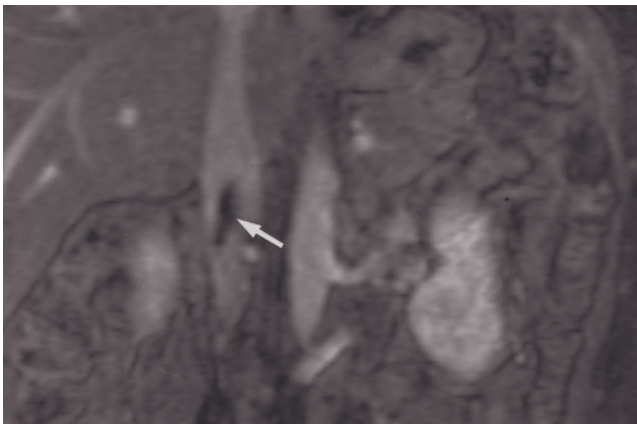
IVC thrombosis. Transverse 45-s (*a*) and sagittal 90-s (*b*) postgadolinium SGE images. Bland thrombus (arrow, *a*, *b*) appears nearly signal void on gadolinium-enhanced SGE images. The 45-s postgadolinium SGE image (*c*) in a second patient demonstrates low- to intermediate-signal-intensity thrombus (arrow, *c*) attached to the posterior wall of the IVC. The combination of intense enhancement of the IVC on gadolinium-enhanced SGE images with multiplanar imaging makes MRI an excellent, minimally invasive modality for the assessment of venous thrombosis. Gadolinium-enhanced interstitial-phase SGE images (*d*, *e*)
